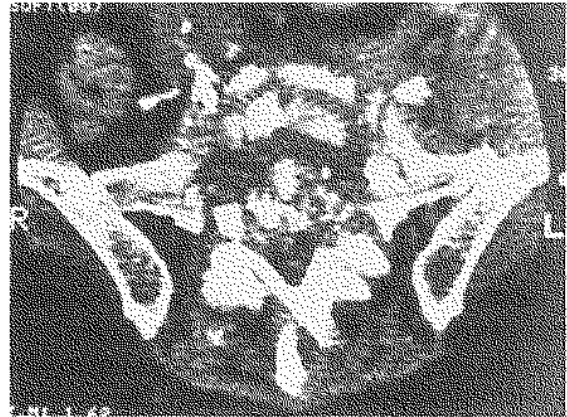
CT-Scan of the lumbosacral column showing the destruction of the body of L₅ and the upper surface of S₁ with reduction in the diameter of the spinal canal and narrowing of both foramina.
